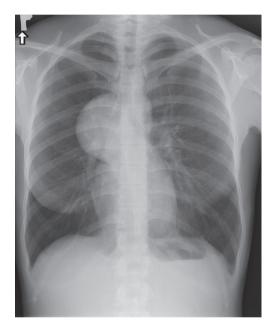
X-ray shows a tumor size of 90 mm \times 60 mm in the area of the right pulmonary hilum.
